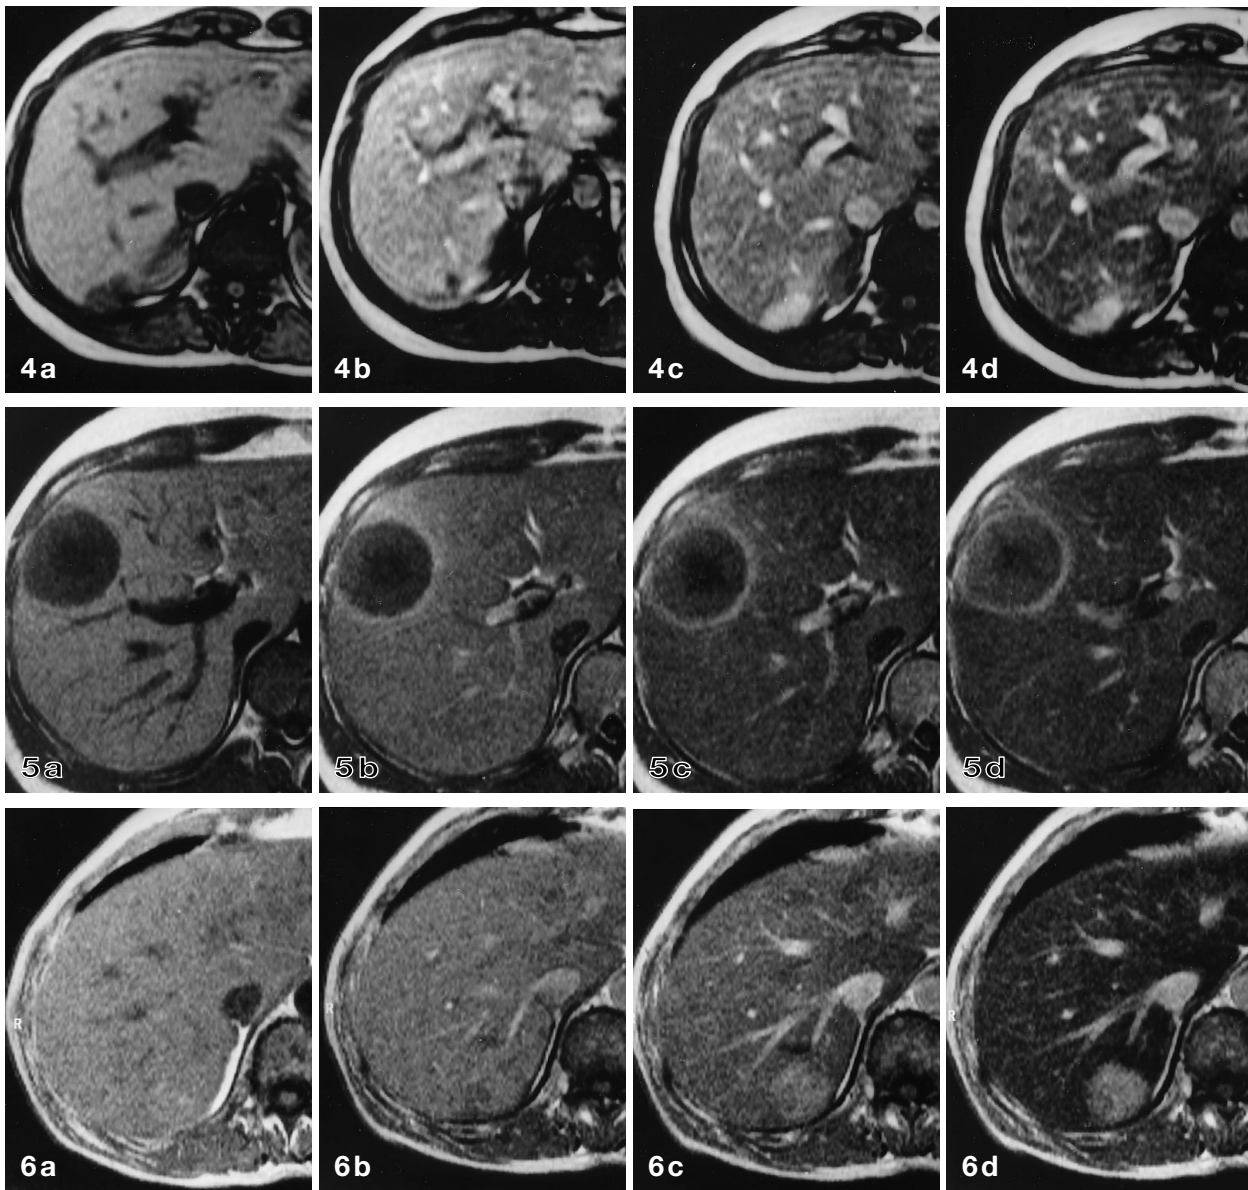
Dynamic signal changes of benign lesions: hemangioma. Dynamic SH U 555 A-enhanced T1-weighted images (a pre-contrast; b 60 s; c 240 s; d 400 s) of a patient with a liver hemangioma in the right liver lobe. Dynamic changes in tumor signal with early peripheral signal enhancement and subsequent filling-in of the hemangioma are demonstrated
